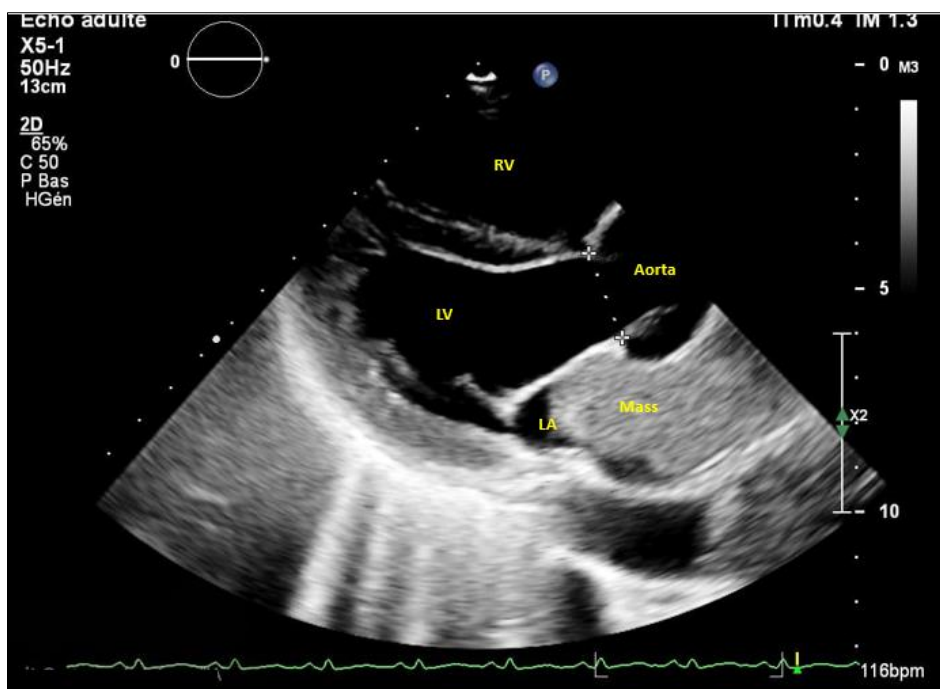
Parasternal long axis view revealing a mass in the left atrium (TTE)
